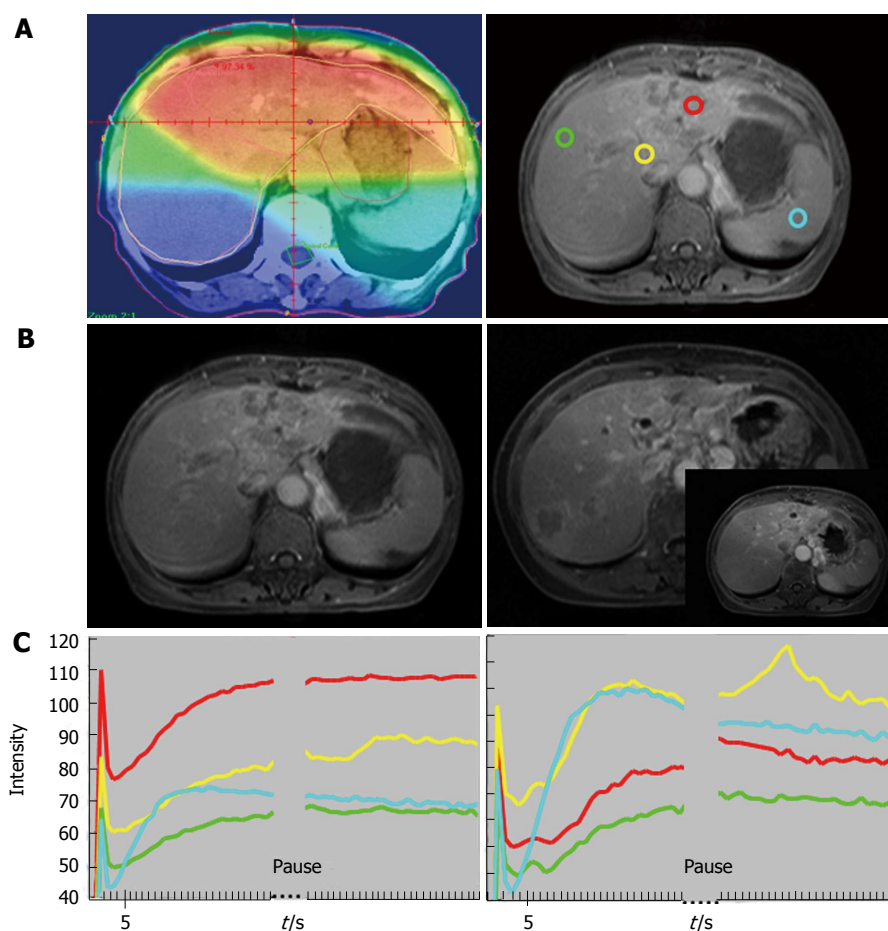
Sixty-four-year-old woman with good local response and intrahepatic recurrence outside of RT fields. A: Isodose distribution and region of interests (ROIs): Left panel: isodose distribution on center section of radiation treatment planning. Red: 45 Gy; orange: 40 Gy; yellow: 30 Gy; green: 15 Gy; blue: < 15 Gy. Right panel: ROIs on magnetic resonance imaging (MRI) before RT: red: tumor with strongest enhancement; yellow: non-tumor liver parenchyma receiving 30 Gy; green: non-tumor liver parenchyma receiving 15 Gy; blue: spleen; B: T1 weighted contrast-enhanced MRI before RT (left panel, same site as the right panel of (A) and after RT (right panel). The intersect picture of MRI over right panel demonstrates no tumor progression in the RT field on the center section of treatment planning. Arrows indicate tumor margins and arrowhead, recurrent tumor outside the field of RT; C: Time Intensity Curve of ROIs before RT (left panel) and at week 2 of RT (right panel). Red: tumor; yellow: 30 Gy; green: 15 Gy; blue: spleen. The initial spike due to refocusing artifact will not be counted into analysis. (From reference [23], reprint with permission).
